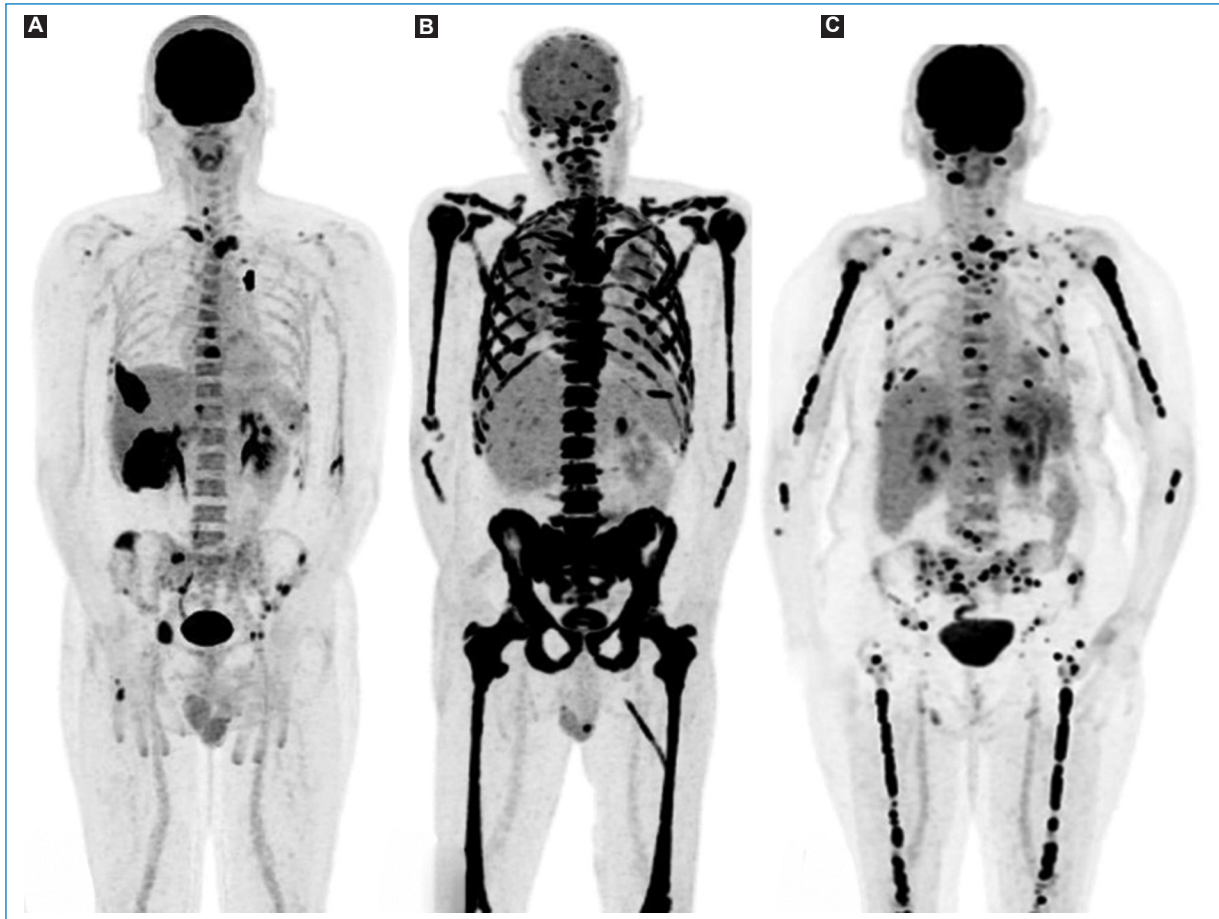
Bone marrow infiltration patterns on FDG PET/CT MIP image: focal pattern with multiple focal hypermetabolic lesions in pelvic bones, ribs and vertebrae (A), diffuse pattern with diffusely increased uptake of the axial and appendicular bone marrow (B) and mixed pattern with diffuse uptake of the appendicular and multifocal bone marrow in the axial skeleton (C).
